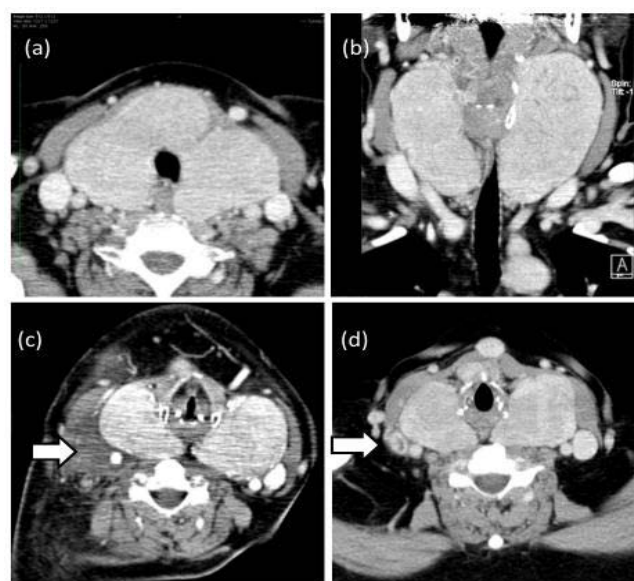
Computed Tomography (CT) of the thyroid in case1. (a) Horizontal and (b) vertical dislocation of pre treatment phase was revealed the enlargement in both sides of thyroid tumor. (c) After plasmapheresis phases that the occlusion of right internal jugular vein (solid white arrow) and perivasculitis was shown. (d) Three weeks later, perivasculitis was disappeared and the blood flow around the rt. internal jugular vein was partially recovered (solid white arrow).
